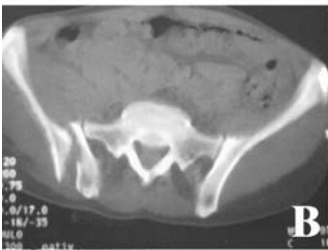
Type C patients with fractured anterior rami. (A) The patient sustained Subtype C1 injury with anterior injury as the form of fractured anterior rami. Plain anteroposterior x-ray film demonstrates rotational deformity and vertical translation of the right pelvis. (B,C). Preoperative CTs show internal rotation of the right pelvis. (D) Reduction and stabilization was performed using the iliac rod and S1 pedicle screws. Postoperative x-ray film demonstrates sufficient reduction of rotational and translational deformity. (E) Postoperative CT shows sufficient correction of rotational deformity.
